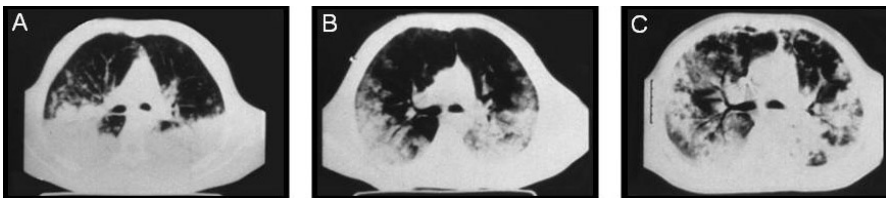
CT scan slices taken at different ARDS stages: (A) early ARDS (1 week); (B) intermediate ARDS (2 weeks); (C) late ARDS (<3 weeks)
